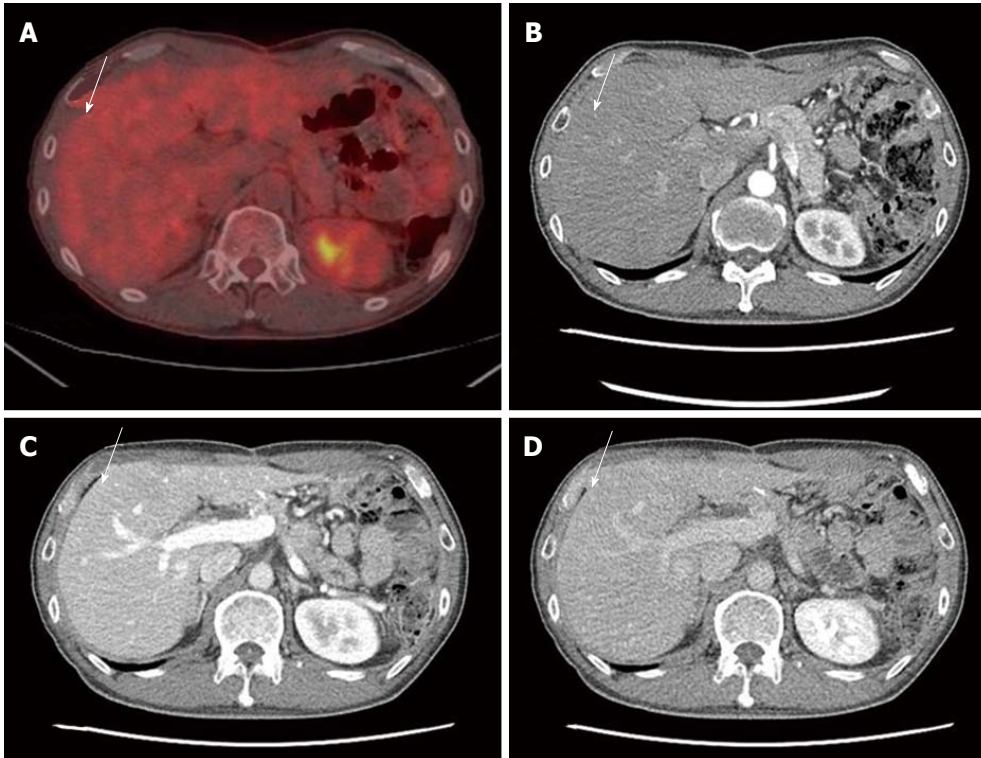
After adjuvant chemotherapy without oxaliplatin, the arterial enhance lesion disappeared. A: PET CT; B: Arterial phase image; C: Portal phase image; D: Delayed phase image.
